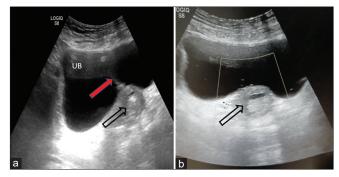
Pseudoaneurysm (open black arrow a) was accessed through the percutaneous transcystic route using a 22G Chiba needle (red arrow a) and 0.5 mL of 33% glue (N-butyl cyanoacrylate)-Lipiodol mixture was injected; postembolization image (b) Shows echogenic content within the pseudoaneurysm with no residual flow on Doppler, suggestive of complete thrombosis. A note is made of a few floating echogenic debris within the UB, as seen in image (b), due to the dislodgement of a few glue-Lipiodol particles into the UB lumen UB while removing the Chiba needle. UB: Urinary bladder
